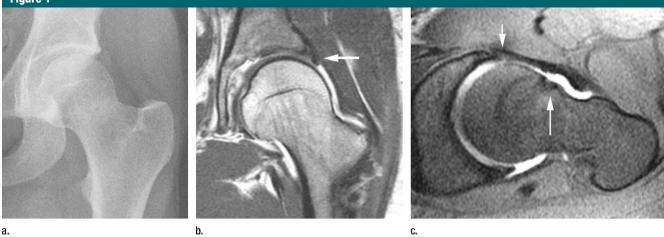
Preoperative images of left hip in 19-year-old man with clinical signs and symptoms suggesting FAI. (a) Anteroposterior radiograph shows no degenerative change. (b) On coronal T1-weighted MR arthrogram (repetition time msec/echo time msec, 550/14), acetabular labrum (arrow) and adjacent articular cartilage show no tear or defect. (c) On oblique axial fat-suppressed T1-weighted MR arthrogram (625/15), small size and irregular contour of anterior acetabular labrum (short arrow) suggest degeneration and tear. Bony proliferative changes (long arrow) involve head-neck junction of proximal femur.
